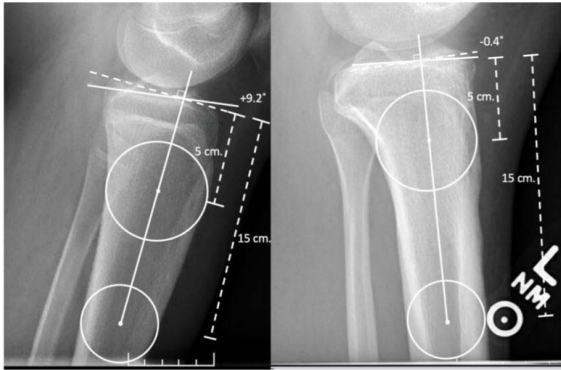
Posterior tibial slope angle measurements (PTSA) for a posterior cruciate ligament (PCL) deficient knee and a matched control. Panel A depicts a lateral radiograph for a healthy knee control patient, utilizing the circle method for measuring PTSA and demonstrating a relatively posterior tibial slope denoted with a positive angle. Panel B depicts the circle method on a lateral knee radiograph on a patient who suffered a PCL tear, demonstrating relatively anterior slope denoted with a negative angle.
